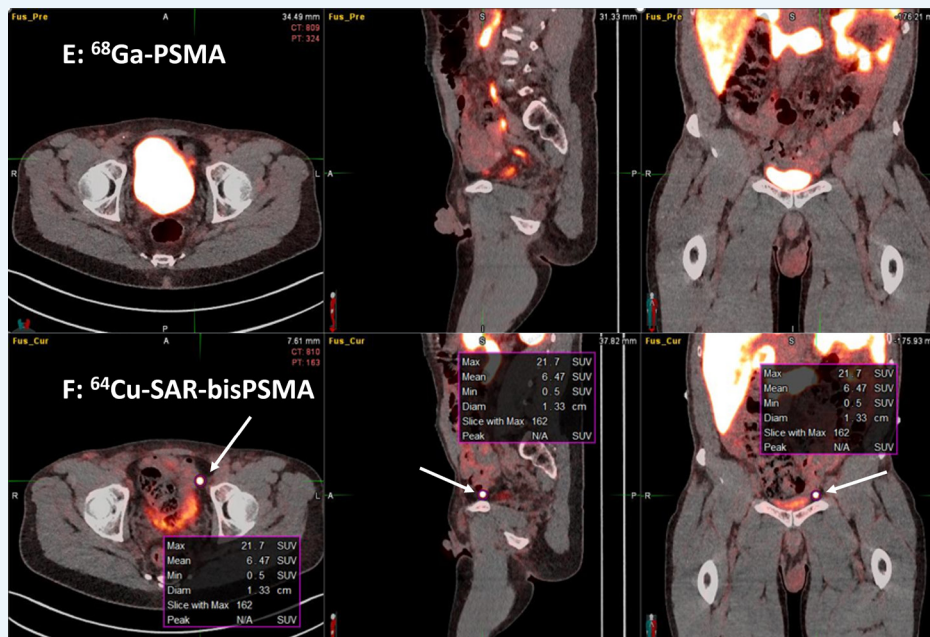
Scans from a third patient show uptake of ⁶⁴Cu SAR-bisPSMA in a pelvic lymph node (image F in the bottom row), outside of the prostate. This lesion was not detected by the readers on the ⁶⁸Ga PSMA-11 scan (image E in the top row).
